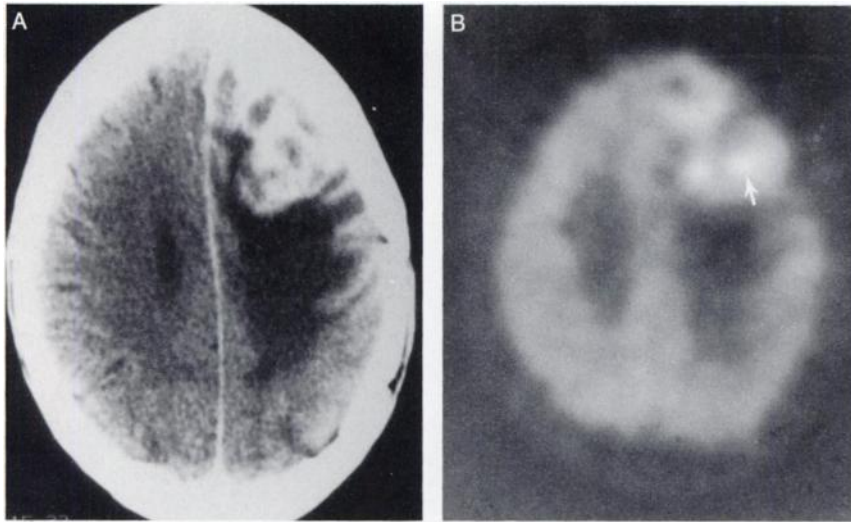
Patient 6 (Table 1). Contrast-enhanced CT scan (A) shows a large enhancing left frontal mass. FDG-PET scan (B) shows a hypermetabolic inhomogeneous lesion (arrow) localized to the left frontal lobe. This lesion was CNS lymphoma.
